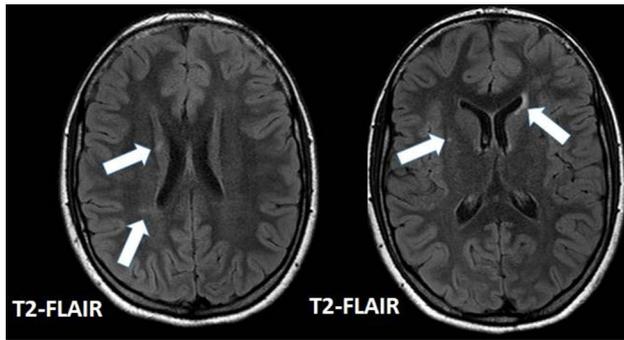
Patient 14: T2-weighted/FLAIR hyperintense remote ischemic changes in bilateral periventricular white matter and head of right caudate with tiny chronic ischemic insults (white arrows)
